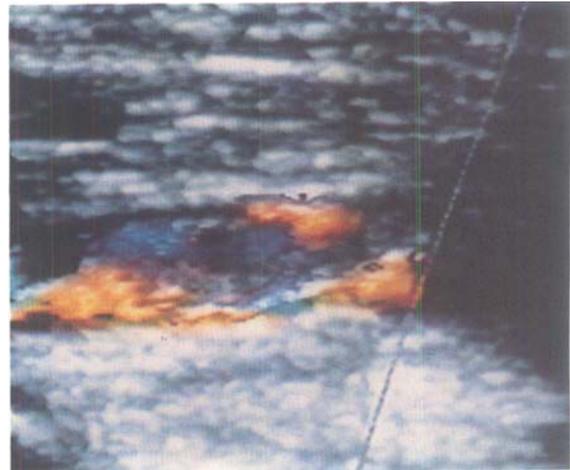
Colour Doppler ultrasonographic image showing the lumen of an entrapped popliteal artery partially filled with loose thrombus. Blood (red) can be seen flowing around the thrombus, which tends to fragment causing distal embolization
